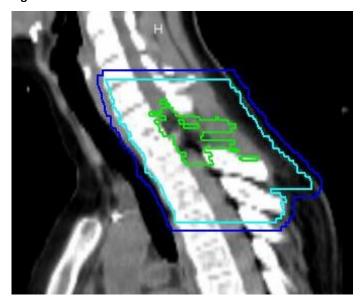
Post-surgical sagittal planning CT slices following decompression of C7/T1 and chemotherapy for Ewing's sarcoma of the spine at C7/T1. Green – GTV; Turquoise – CTV_5400; Dark Blue – PTV_5400.
